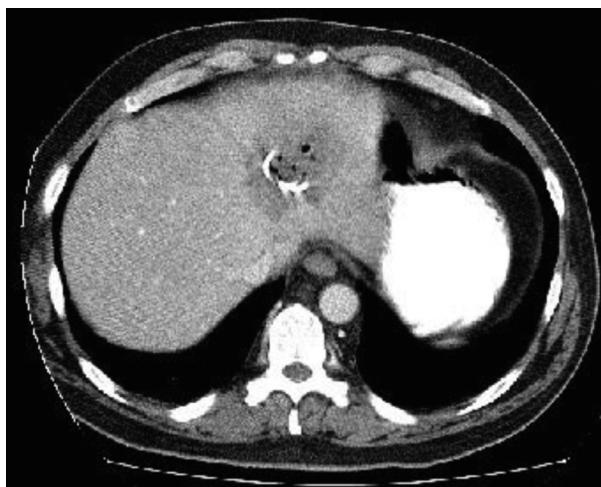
Abscess and drainage catheter are seen in the CT performed at the 21st day of the treatment.
